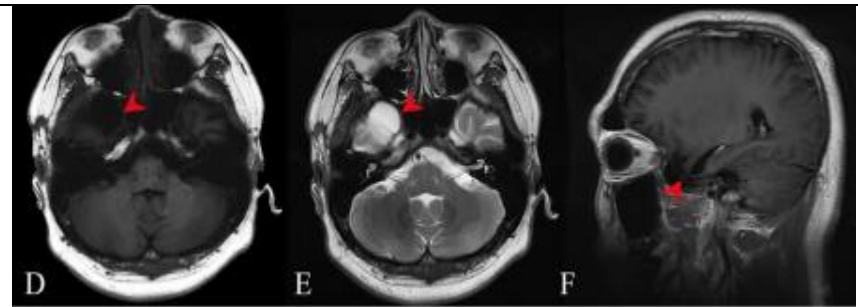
(D,E,F):six months after the surgery, follow-up MR imaging revealed increased T1 and T2 signal intensity but no localised enhancing lesion in the right temporal lobe, demonstrating post-operative modification without residual cancer.
